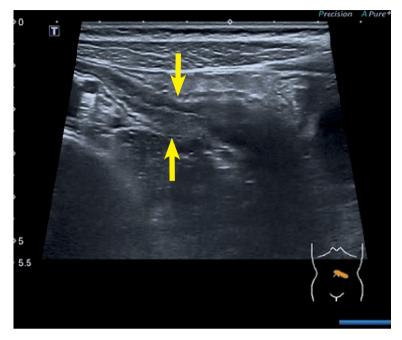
Ultrasound (US) of a jejunal segment with a thickened bowel wall.
